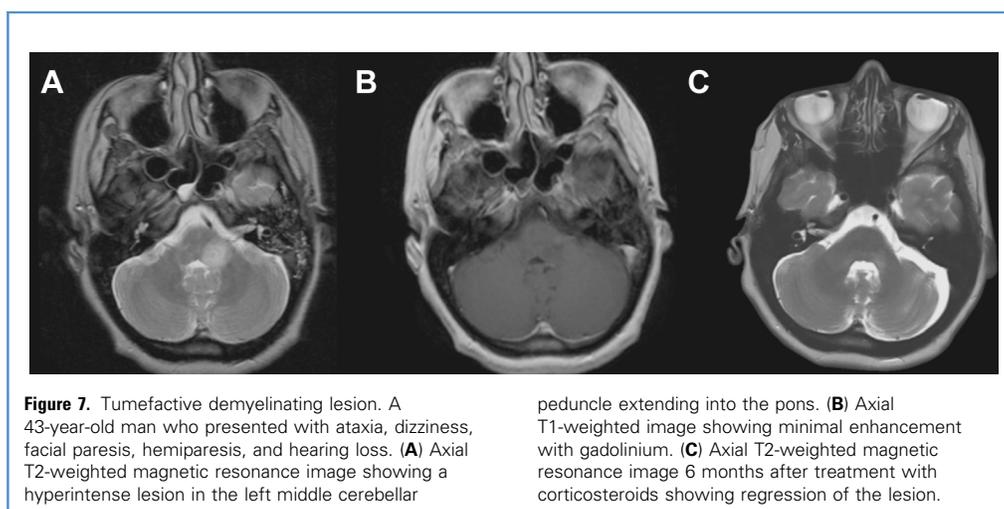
Tumefactive demyelinating lesion. A 43-year-old man who presented with ataxia, dizziness, facial paresis, hemiparesis, and hearing loss. (A) Axial T2-weighted magnetic resonance image showing a hyperintense lesion in the left middle cerebellar
